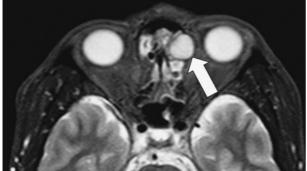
Magnetic resonance imaging showing a cystic lesion in the left ethmoid sinus (arrows).
